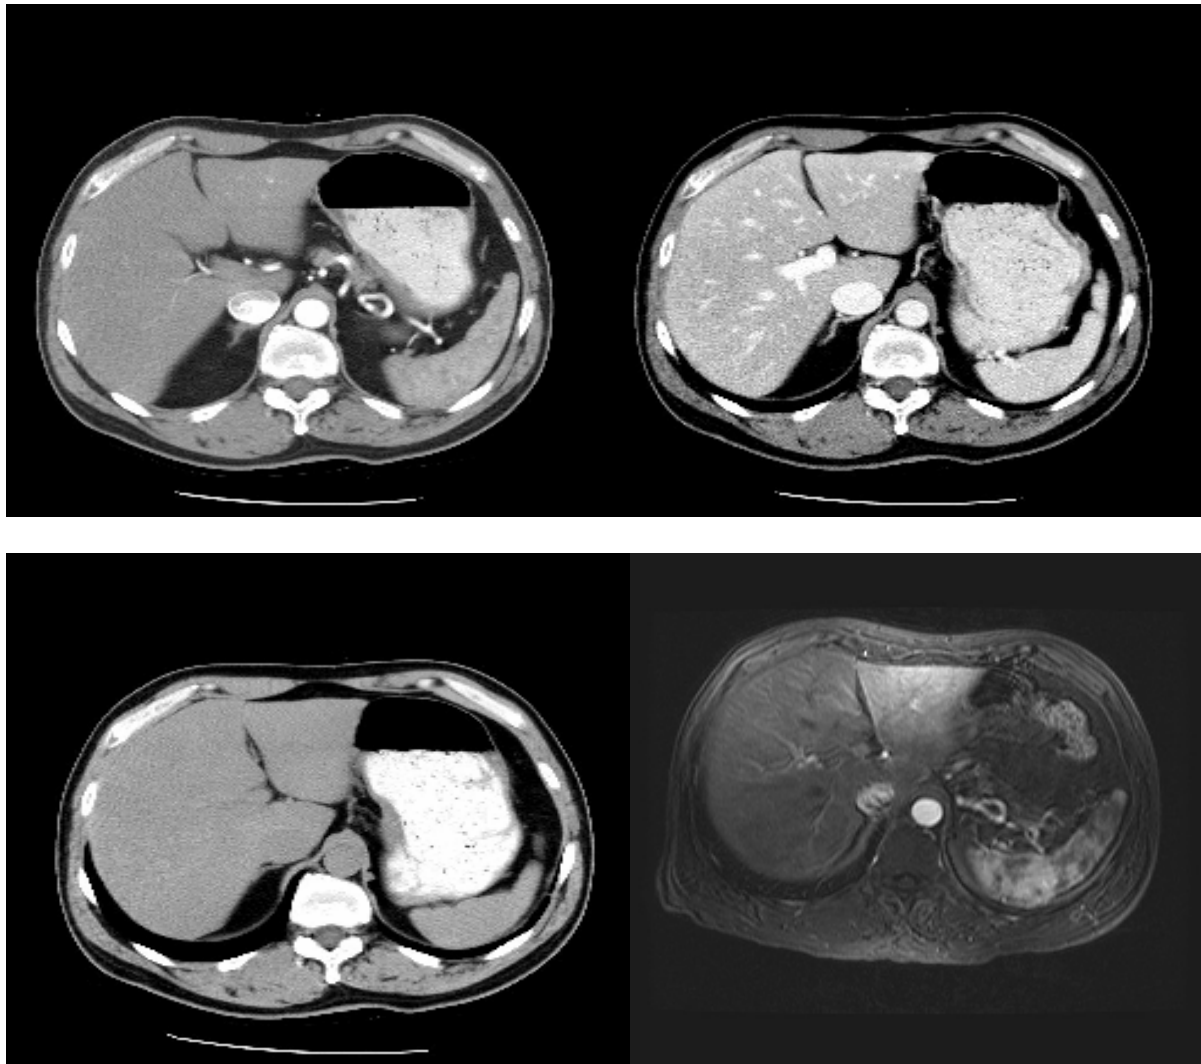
Example CT/MR image set: (upper left) hepatic phase, (upper right) portal phase, (lower left): pre-contrast, (lower right) MR hepatic phase.
